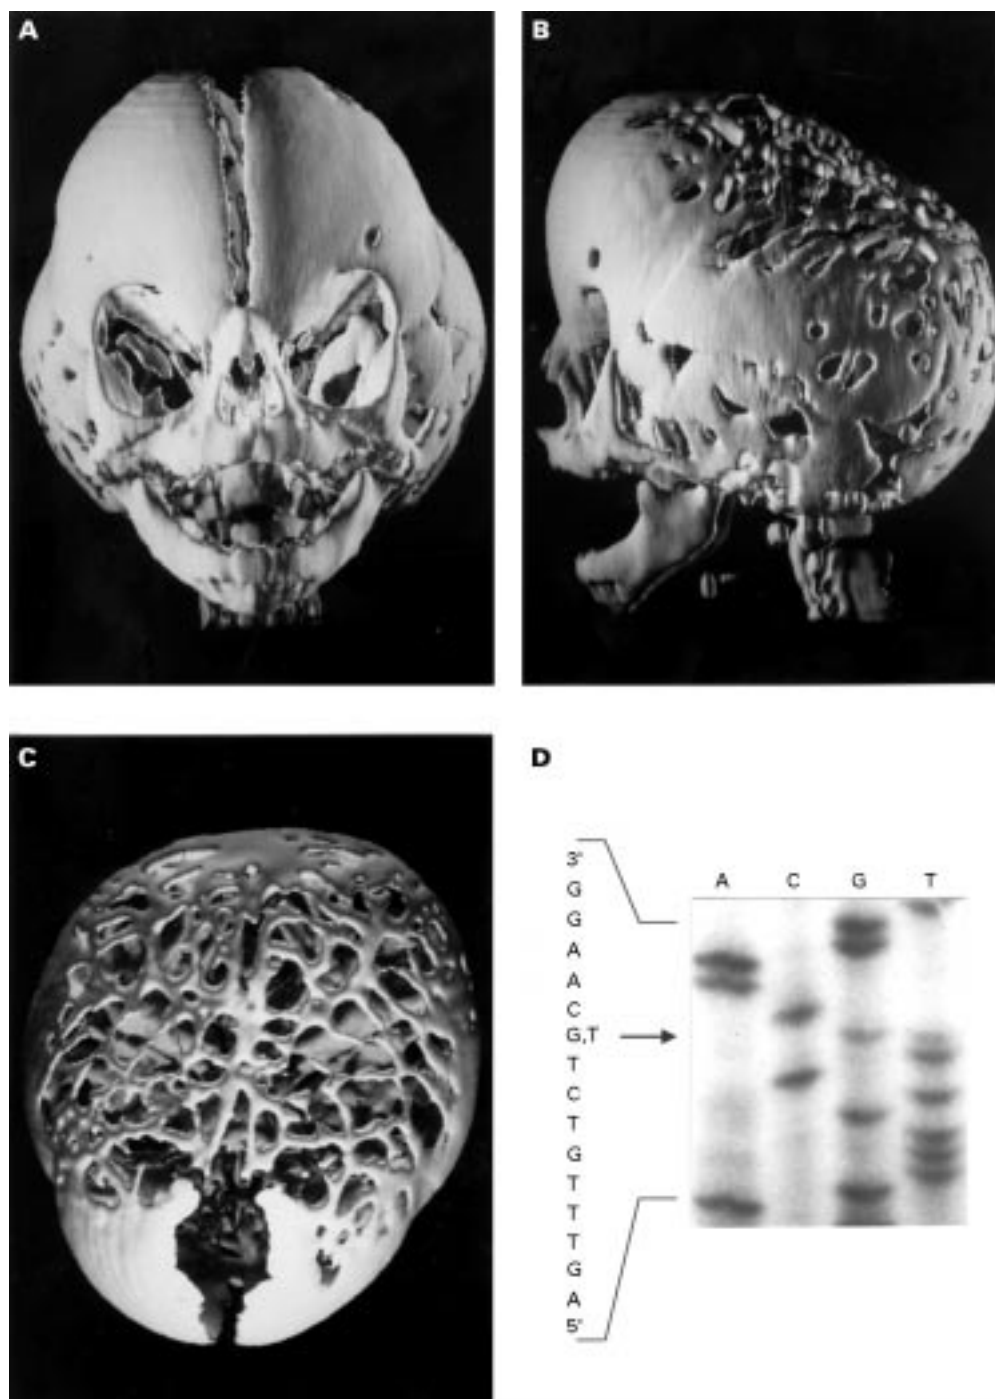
3D computed tomography of the patient's skull at 3 months (A-C). (D) DNA sequence of exon 7 showing a G→T transversion at nucleotide position 833 (counted from the first base of the start codon ATG). This results in the exchange of a cysteine for a phenylalanine at amino acid position 278.
